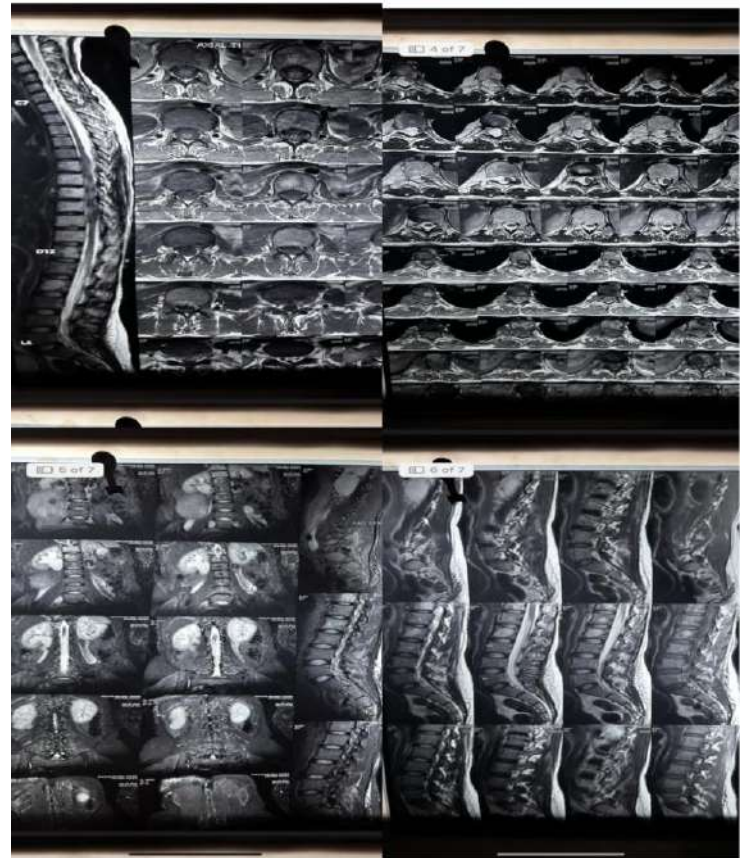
Thoracic spinal MRI showing a well-defined, solid, extramedullary mass lesion at T6–T10 levels, compressing and displacing the spinal cord
